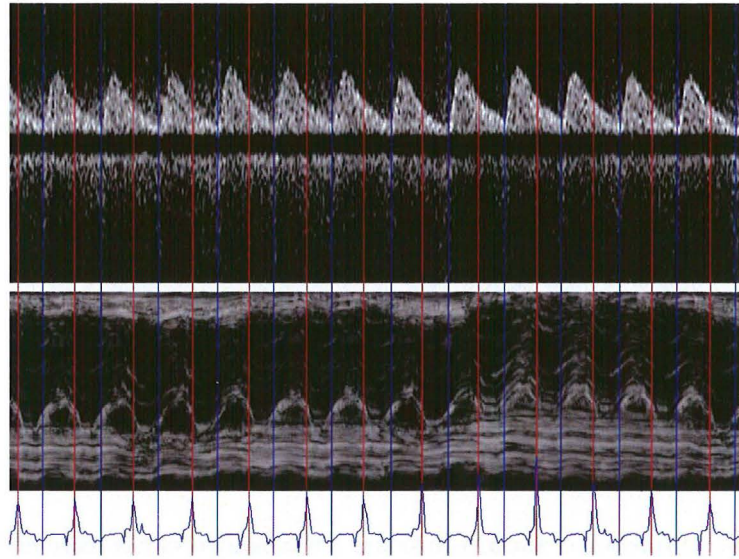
Doppler CW data through the umbilical artery and M-mode data through the atrioventricular area, as well as the tissue Doppler trigger signal. The M-mode and the trigger signal were both generated from a B-mode loop with 2D tissue Doppler. The blue line shows the basic signal from which the trigger signals (red bars) are automatically generated. The blue bars show time stamps for start systole, manually selected from the spectrum.
